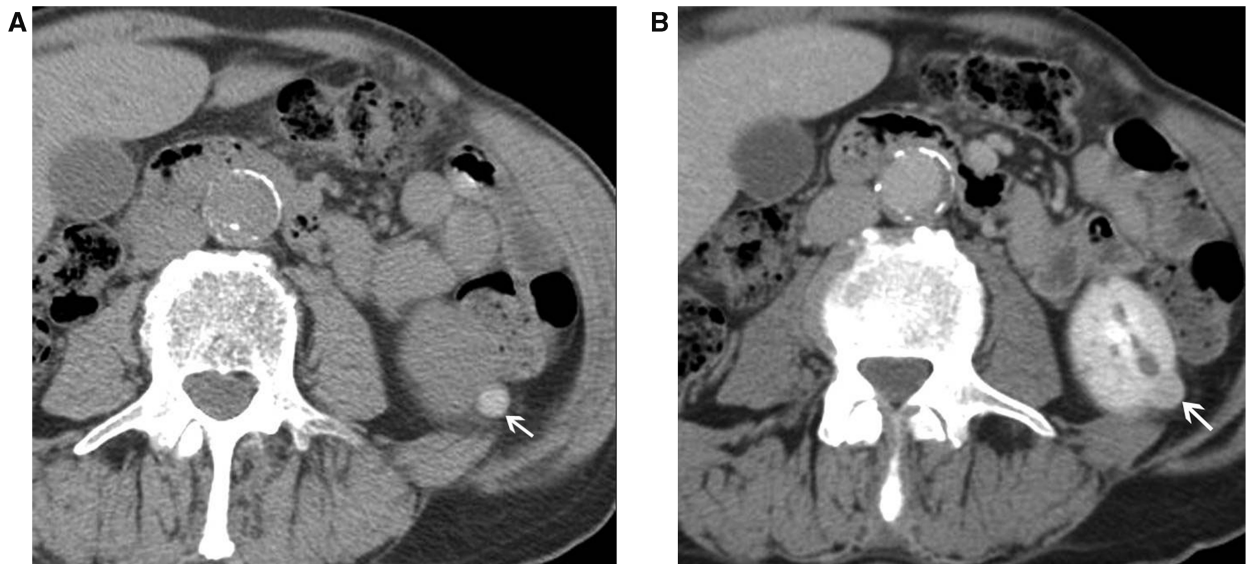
Hyperdense cyst. Axial unenhanced (A) and enhanced (B) CT images show a small left lower pole mass (arrows) which is hyperdense on unenhanced imaging (a) and which shows no significant post-contrast enhancement.
